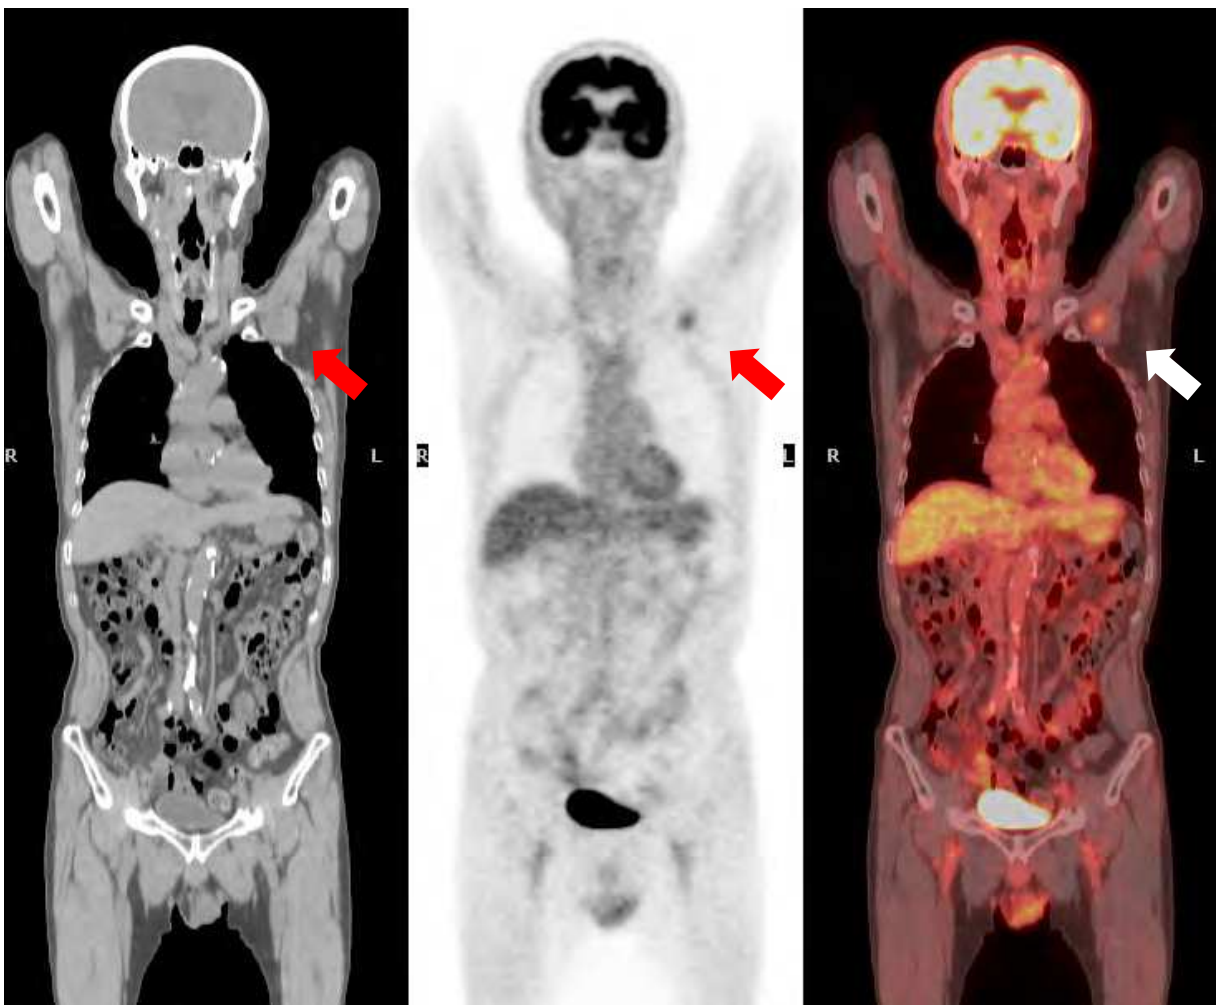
CT, FDG and PET/CT images showing accidental detection of schwannoma in the left brachial plexus.
